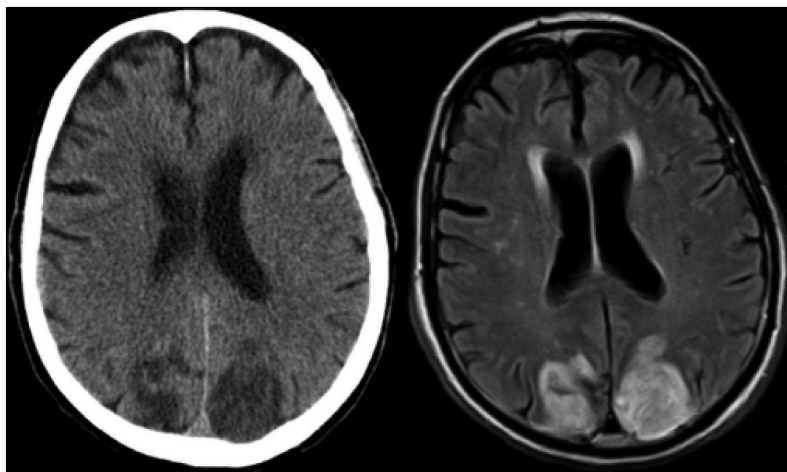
CT brain without contrast revealed bilateral subacute parieto-occipital infarcts (left). MRI of the brain without contrast on FLAIR sequence showed acute to subacute bilateral PCA territory infarcts (right).
